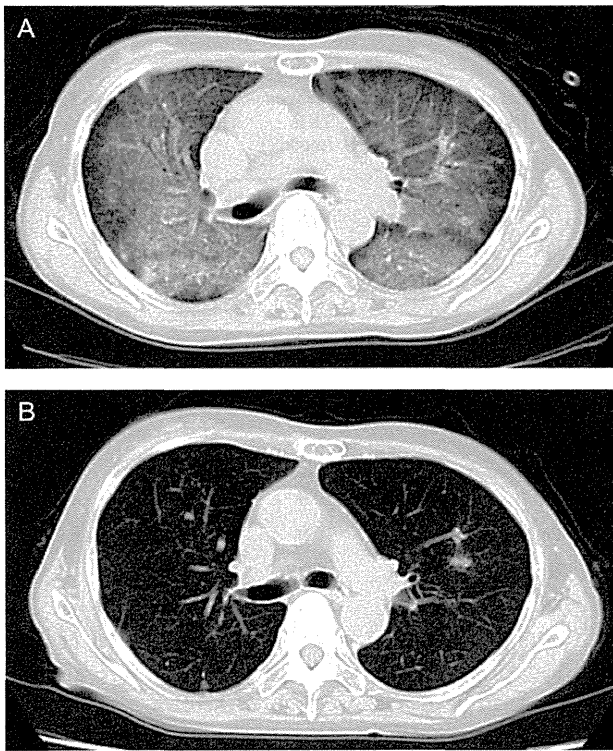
Chest computed tomography (CT) of Patient 1 showed bilateral pulmonary infiltrates on 24 days after initiation of treatment with gefitinib (A). After improvement of gefitinib-induced interstitial lung disease (ILD), chest CT scans demonstrated that no ILD was observed in the patients before treatment with erlotinib (B).
